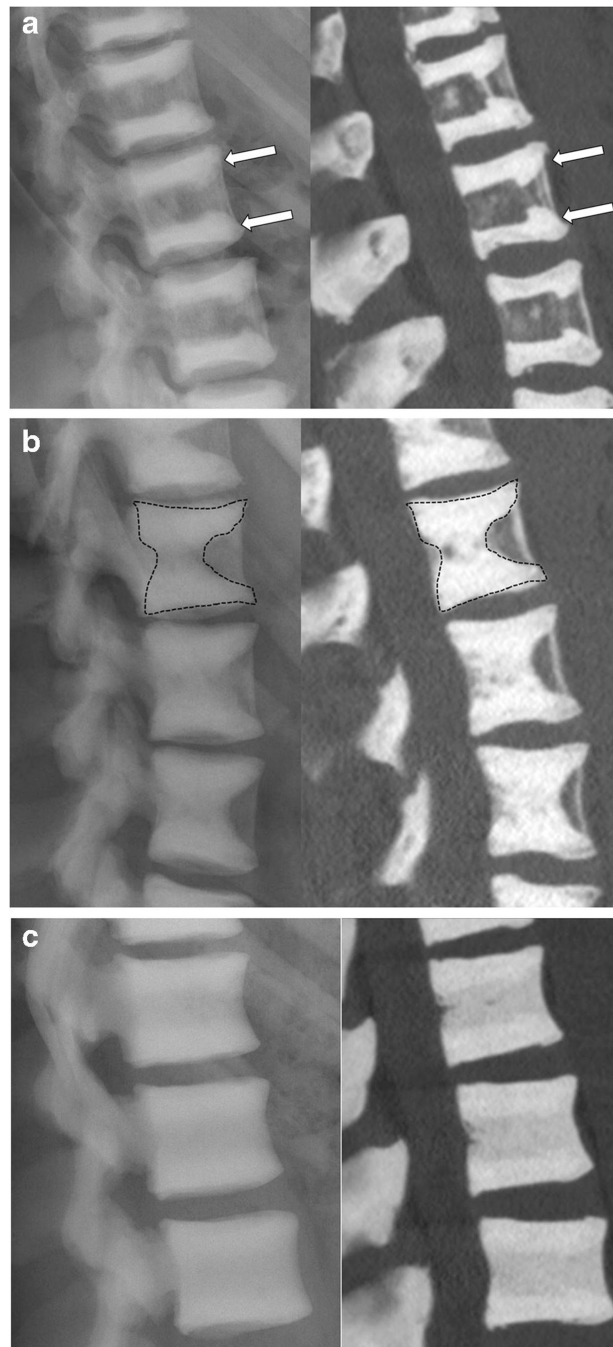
Example radiographs and CT images of each vertebral body sclerosis pattern, including (a) a middle-aged woman with the classic “rugger jersey” pattern of vertebral body sclerosis (parallel bands of increased density at the vertebral body endplates, white arrows), (b) a young adult woman with the “anvil” pattern of vertebral body sclerosis (dense sclerotic bands at the vertebral body endplates with additional central vertebral body intramedullary density, dotted outline), and (c) a middle-aged man with diffuse vertebral body sclerosis.
